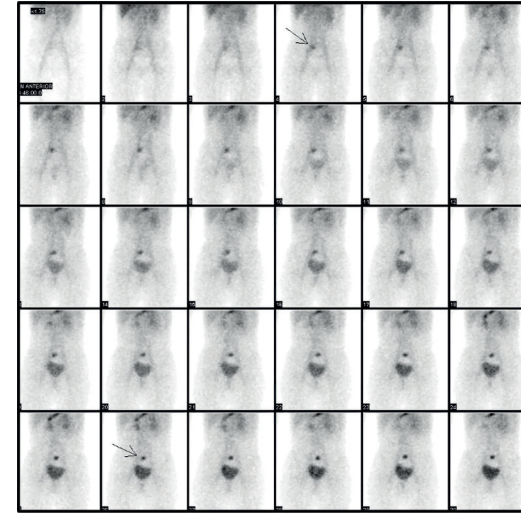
12-year-old girl with low digestive bleeding. Meckel's diverticulum scintigraphy was performed: abnormal focal ^{99m}Tc NaTcO₄ uptake was observed 2–3 minutes after injection (arrow) above the bladder. The scintigraphy findings were related to the presence of ectopic gastric mucosa in the Meckel's diverticulum. Dynamic anterior 1 min/frame images. Premedication with oral cimetidine.
